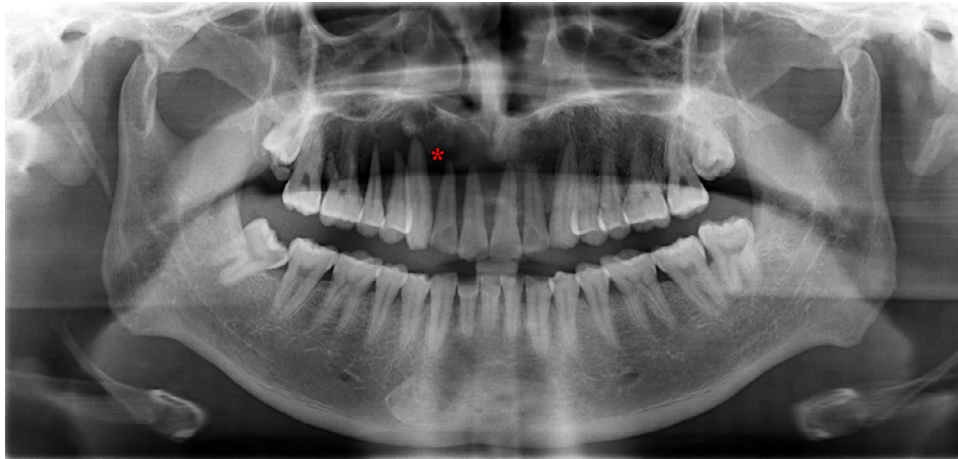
Orthopantomography revealed a radiolucent mass in the right maxilla (asterisk indicated the tumor location).
